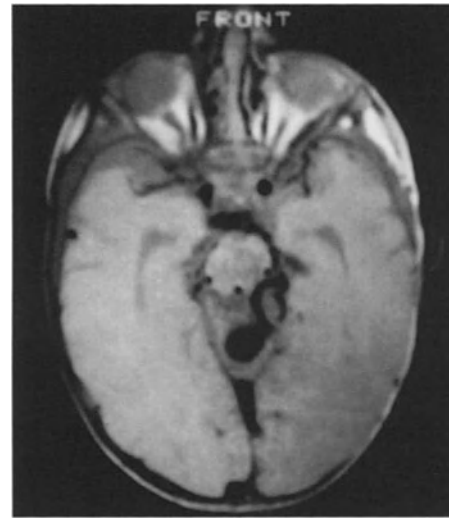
Arteriovenous malformations of the galenic system. This axial projection reveals the dilated vein of Galen posterior to the brainstem, and a large medial posterior choriroidal feeding vessel. This patient was 34 years old at the time this MRI study was performed. He had remained asymptomatic throughout his life, and this was an “incidental” finding.
